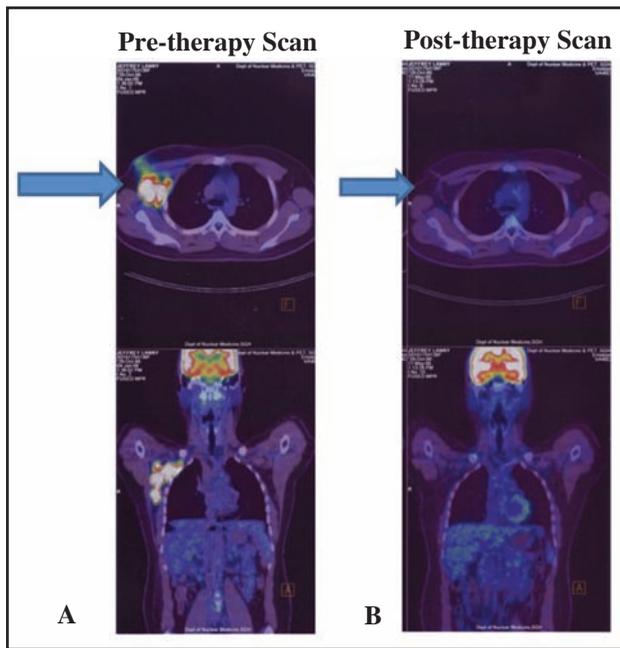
A representative image of FDG-PET/CT scan performed for staging of a patient with non-Hodgkin's lymphoma (a) showing increased uptake in the active disease in the right axilla. The activity clearly disappeared after the patient received chemotherapy as shown on the post therapy scan (b). Courtesy of Professor Ajit Padhy
